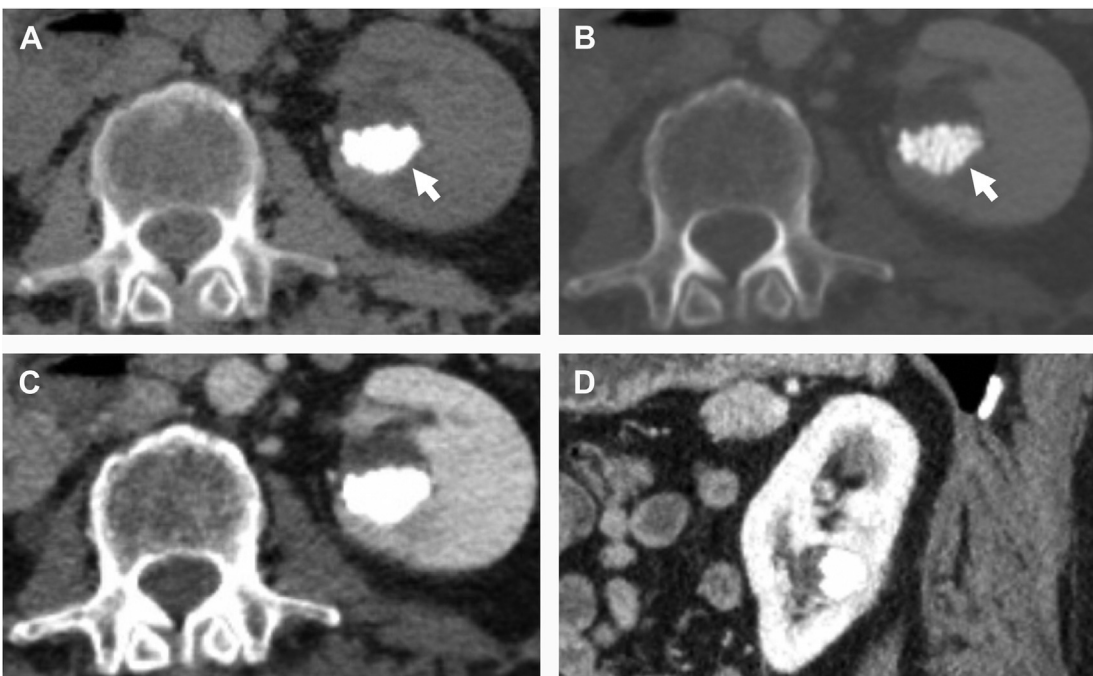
A 57-year-old man with incidental discovery of a left renal cystic mass on a portal venous dual energy CT scan. The virtual nonenhanced images show multiple layering stones (*arrows*) within the renal cystic mass on soft tissue (*A*) and bone (*B*) windows. The cyst walls are thin, smooth, and enhance on contrast-enhanced axial (*C*) and coronal (*D*) images. This was interpreted as a calyceal diverticulum containing stones. No additional imaging was obtained, and the Bosniak classification system was not applied.
